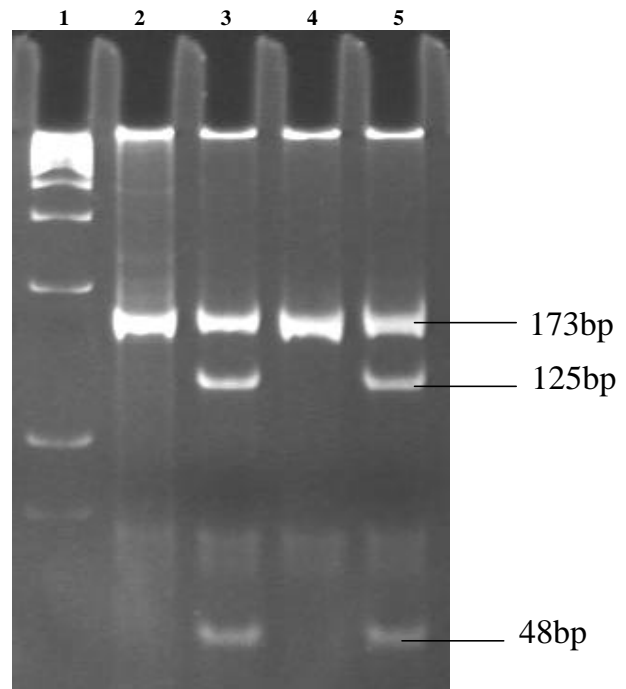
C677T mutation analysis. Lane 1, 100 bp DNA ladder; lane 2, CC (normal); lane 3, CT (heterozygote); lane 4, CC (normal), and lane 5, CT (heterozygote).
